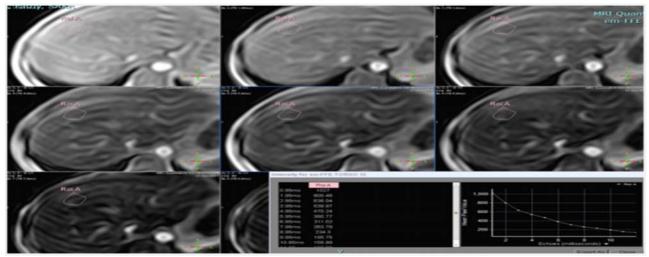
A): MRI assessment of hepatic T2* value with a ROI drawn in the periphery of the right hepatic lobe.
